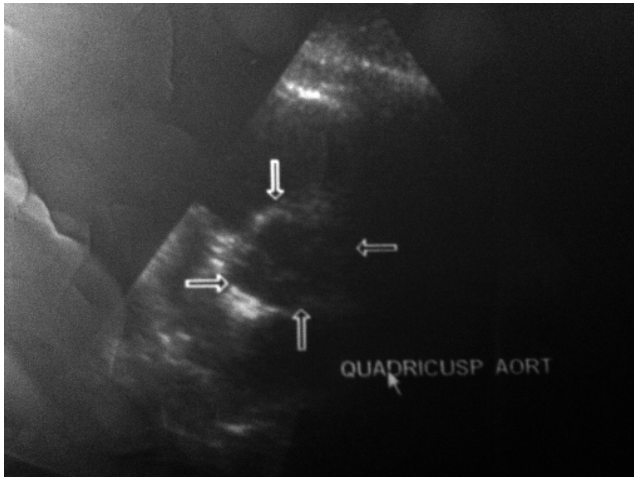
Echocardiographic view.
